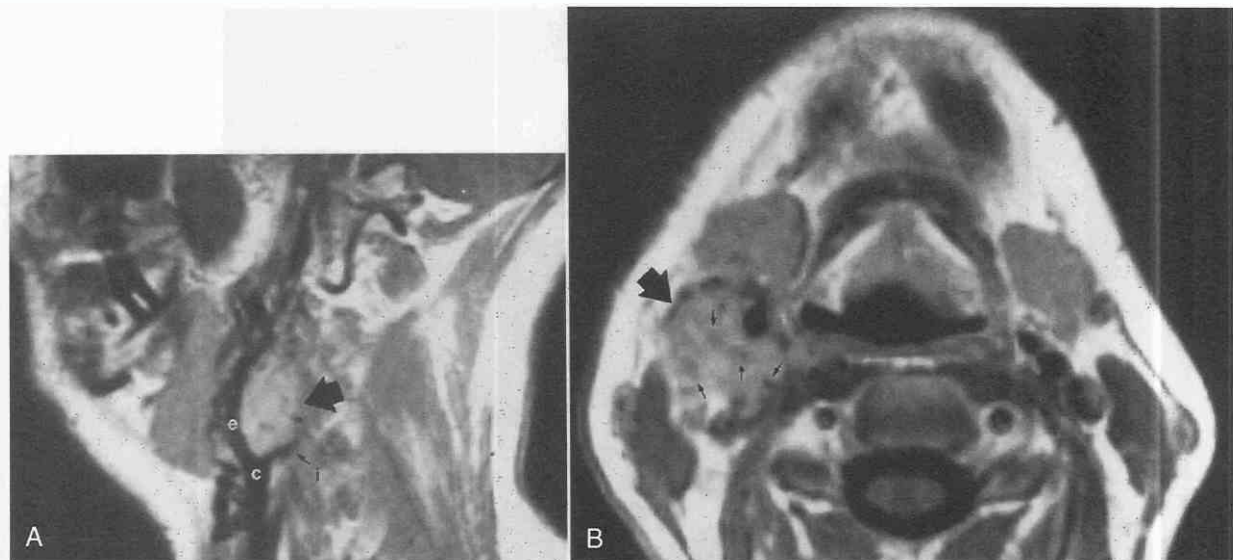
Carotid body tumor. *A*, Sagittal T1-weighted MR image demonstrates a heterogeneous mass (arrow) at the bifurcation of the common carotid artery (c) splaying the external (e) and internal (i) carotid arteries. *B*, Axial T1-weighted MR image at the level of the hyoid bone in the same patient demonstrates a right anterior triangle mass (large black arrow) with multiple internal areas of relative signal void (small black arrows).
